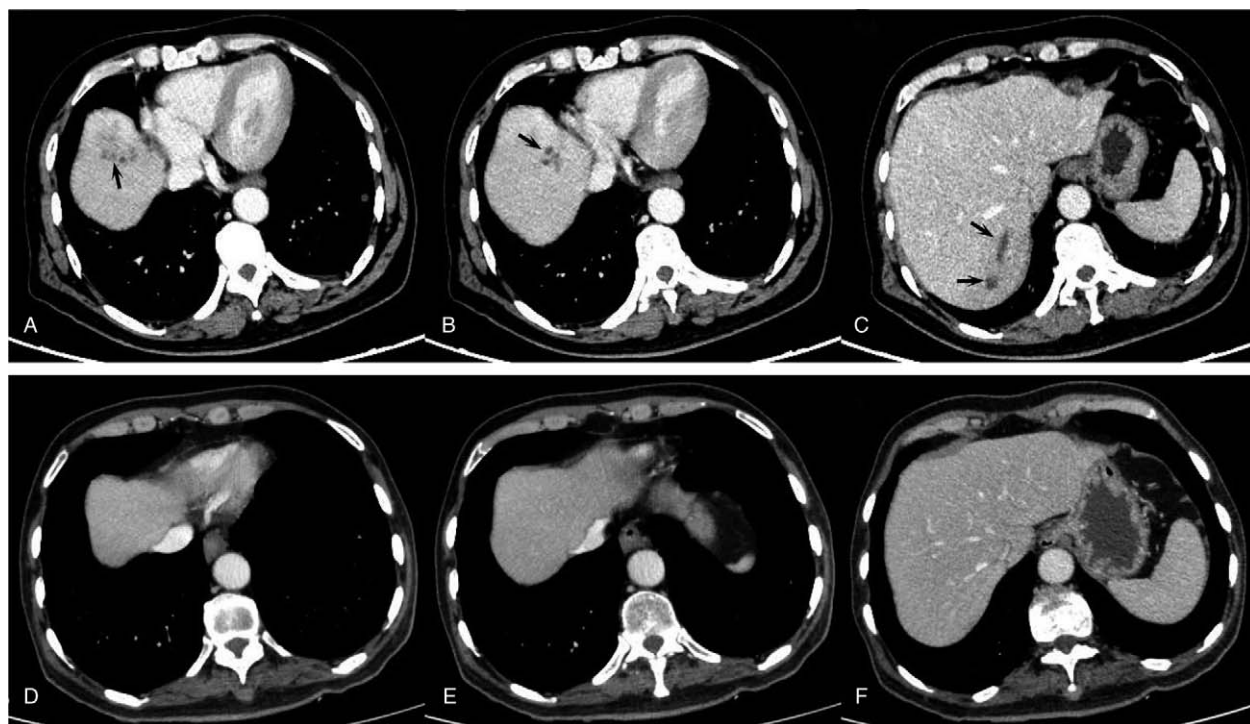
The contrast-enhanced CT scan of the abdomen. (A, B and C) The initial contrast-enhanced CT abdomen images after hospitalization in our hospital. Multiple round mild hypodense areas were observed and are marked with white arrows. (D, E and F) The follow-up CT abdomen images from two months later.
